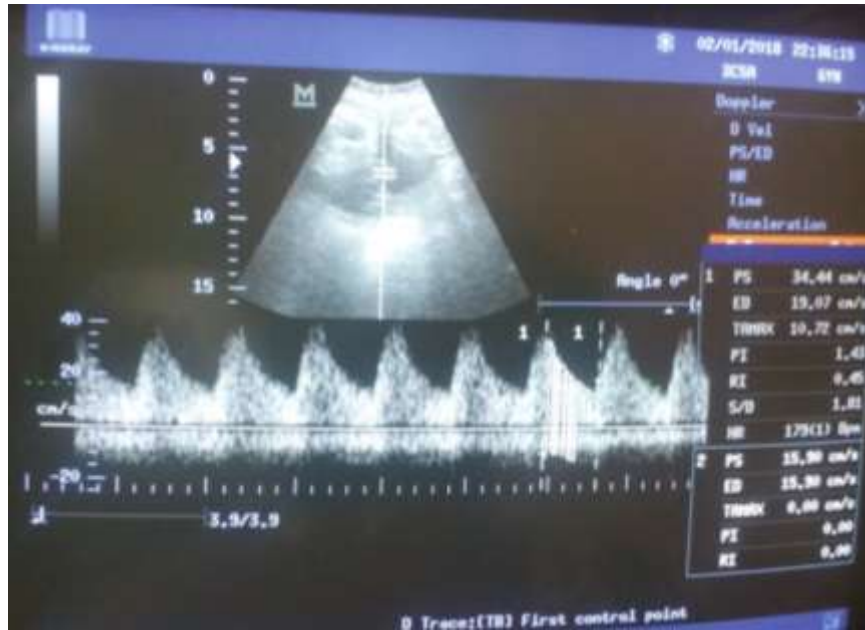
a) shows color Doppler umbilical artery waveform at 43Wks
